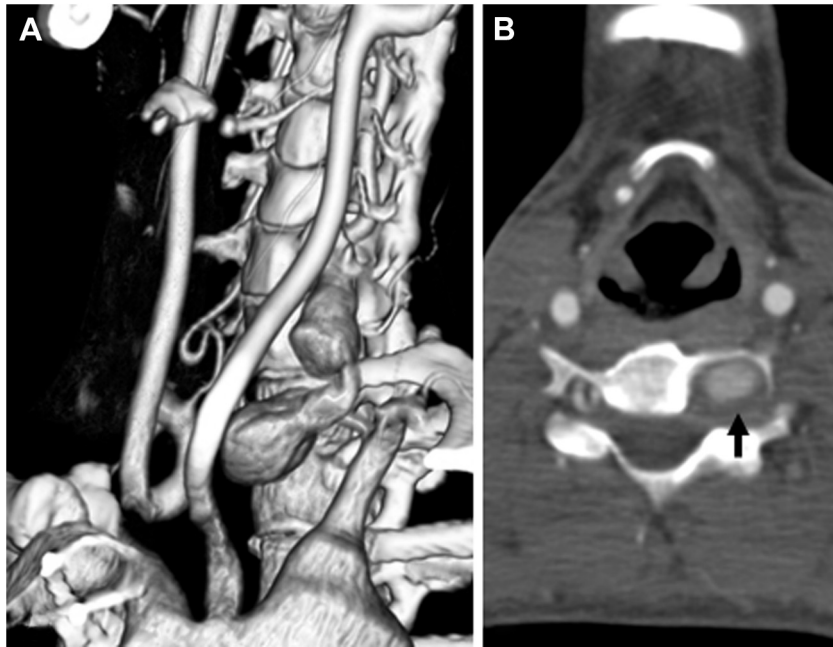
A, A three-dimensional reconstruction of the preoperative computed tomography arteriogram (CTA) demonstrates the left vertebral artery aneurysm. B, CTA demonstrates foraminal erosion and widening, indicated by the *arrow*.
